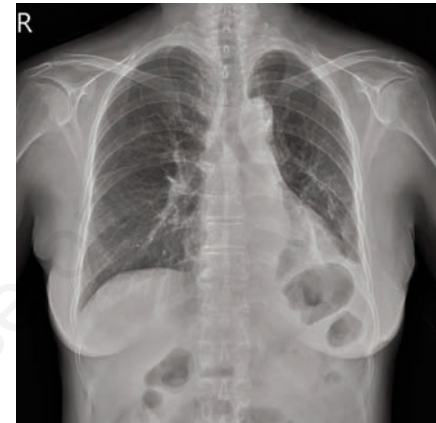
Follow-up chest X-ray image taken 2 months after operation.
